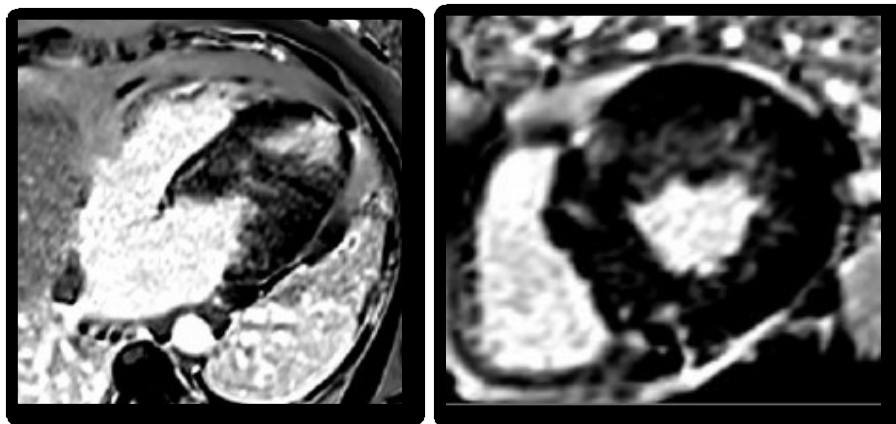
LGE MR image four-chamber and two-chamber view through the same plane shows patchy wall enhancement characteristic of hypertrophic cardiomyopathy
